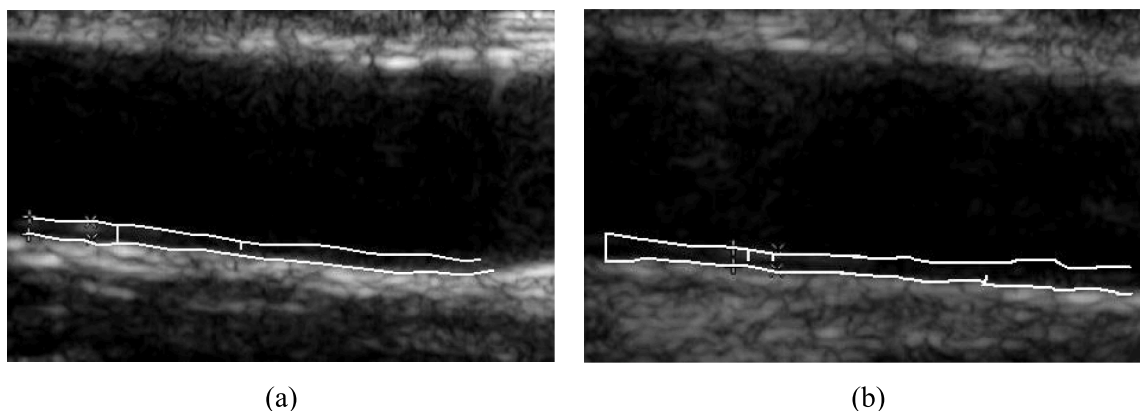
Ultrasound images of the CCA with the semi-automated segmentation of the IMC at the far wall, which represents the layer of the artery mostly affected by atherosclerosis: Mean, median, minimum and maximum values of the IMT for the L side CCA (a) $IMT_{mean} = 0.72$ mm, $IMT_{median} = 0.78$ mm, $IMT_{max} = 0.89$ mm, $IMT_{min} = 0.56$ mm and (b) the right (R) side of the CCA with $IMT_{mean} = 0.97$ mm, $IMT_{median} = 0.93$ mm, $IMT_{max} = 1.24$ mm and $IMT_{min} = 0.73$ mm respectively.
